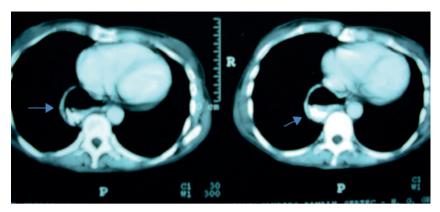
Chest computed tomography showing diverticulum with air-fluid level in posterolateral right side (arrows).
